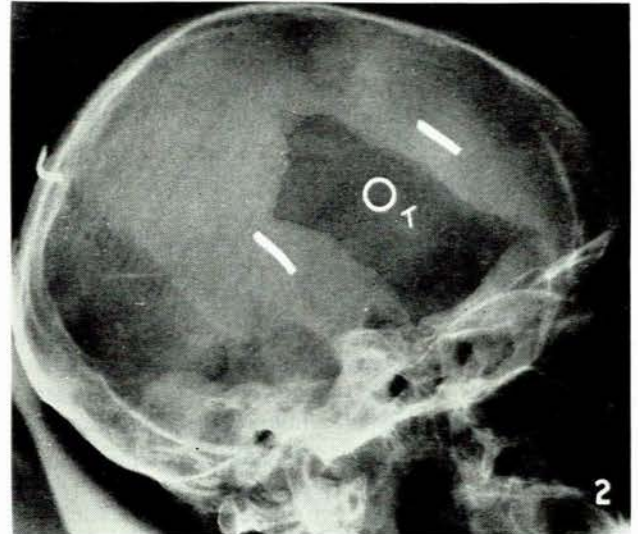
Same case as Fig. 1. X-ray picture of skull defect and markers.
